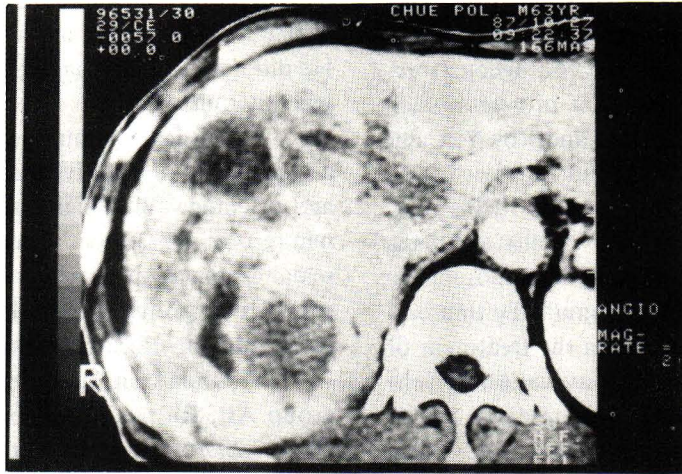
CT-scan of the liver demonstrated the presence of an infiltrative mass lesion with inhomogenous density involving the entire right lobe of the liver, compressing the inferior vena cava.
